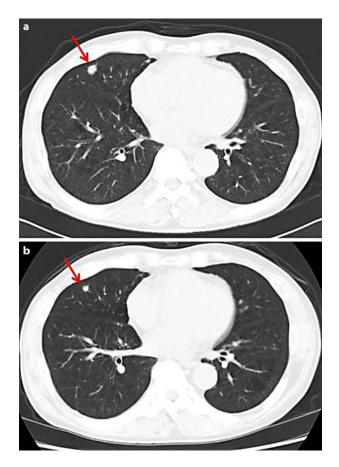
Tumor responses of lung metastases. Computed tomography scan images of the patient's lungs before administration of sunitinib (a) and 2 cycles after initiation of sunitinib (b). Arrows point to the metastatic lung lesion.
